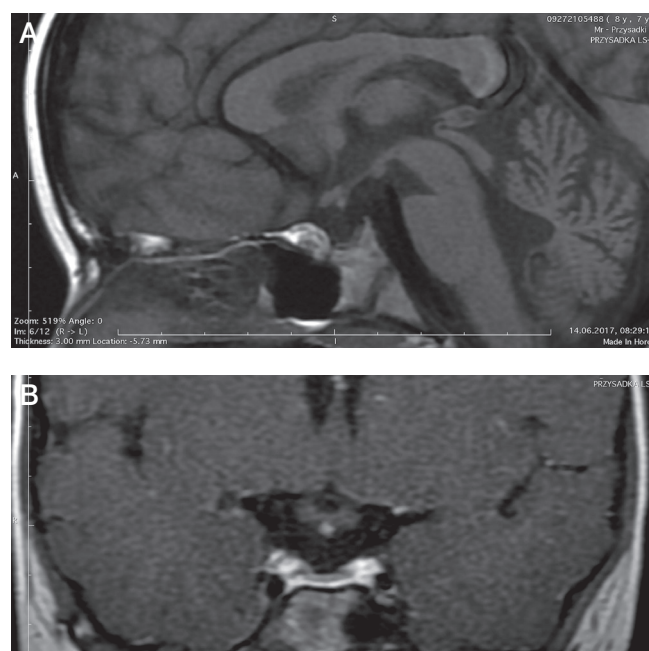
MRI: A) sagittal plain; small, hypotrophic anterior pituitary; B) coronal plain; hyperintense signal of distal regenerating axon of the hypothalamus (pseudo posterior lobe)
